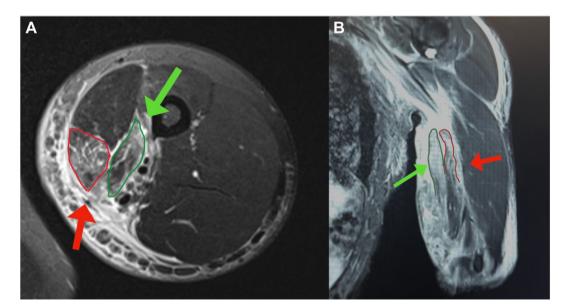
MRI axial image (A) demonstrating the short head of the biceps (*red arrow*) and coracobrachialis (*green arrow*). MRI coronal image (B) showing the short head of the biceps (*red arrow*) and coracobrachialis (*green arrow*) with notable distal retraction. Fraying of the muscle fibers can be observed in what we described as a "mop end" pattern. *MRI*, magnetic resonance image.
